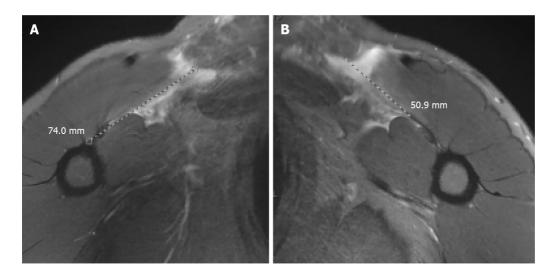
Magnetic resonance imaging of pectoralis major tear. A: 7 cm of retraction on the right pectoralis major tendon; B: 5 cm of retraction on the left pectoralis major tendon.
